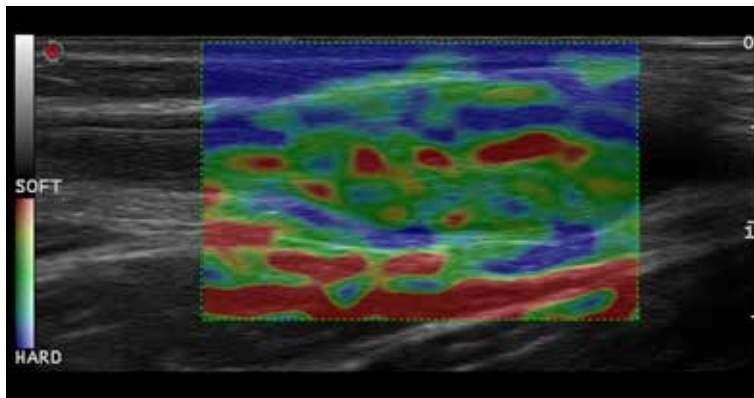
Follow-up ultrasound examination 14 days after detection of the thrombus. US elastogram showing a mosaic of colors.
